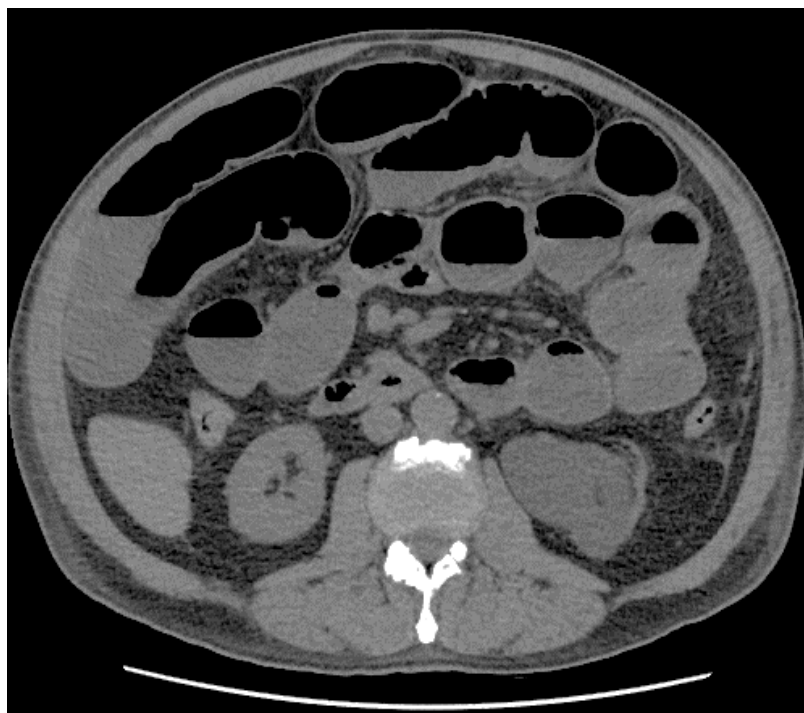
Axial CT scan of the abdomen demonstrating dilated loops of small bowel without a transition point to suggest a mechanical bowel obstruction
